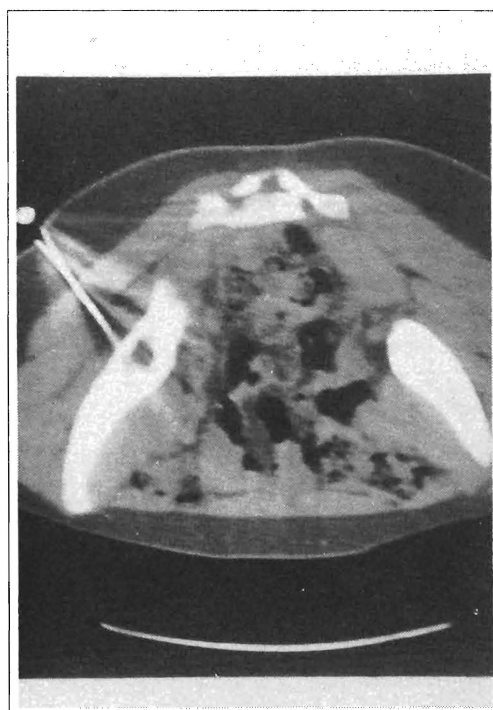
CT scan. Infiltration of lesion with steroid.
